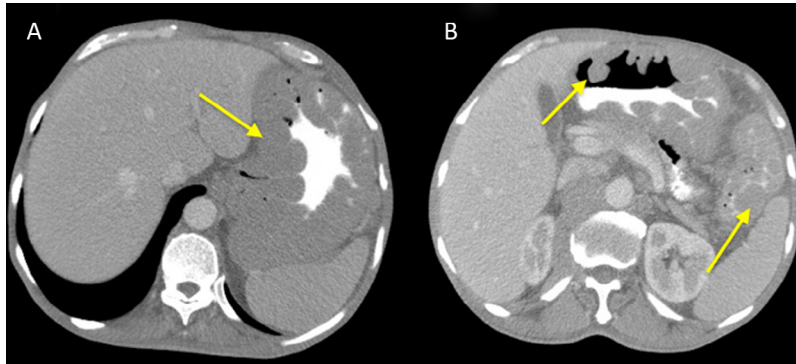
Axial post-contrast computed tomography (CT). (A) Diffuse gastric wall thickening (arrow). (B) Multiple polyps throughout the small bowel and colons (arrows).
